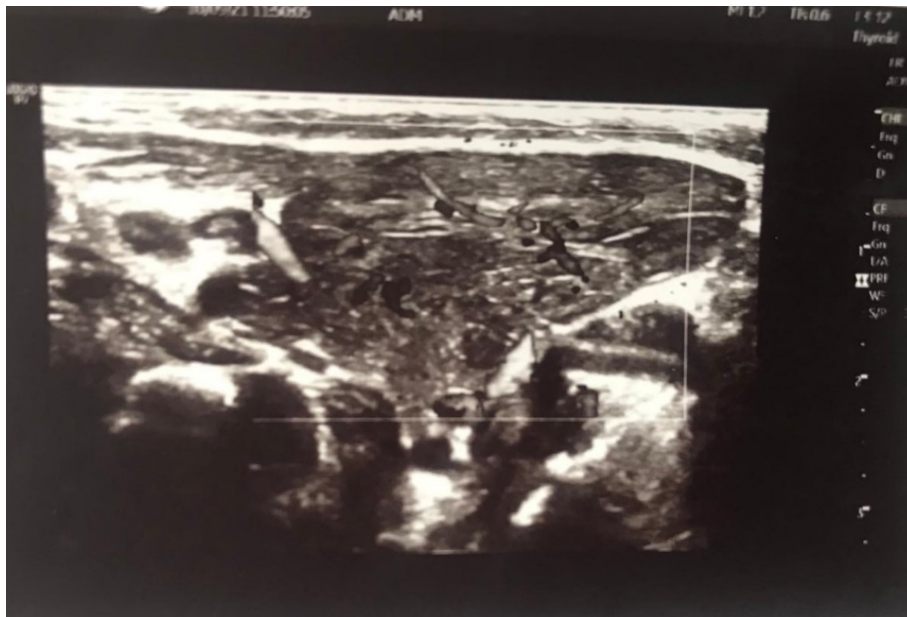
Ultrasound revealed a homogenous solid mass on the neck.
